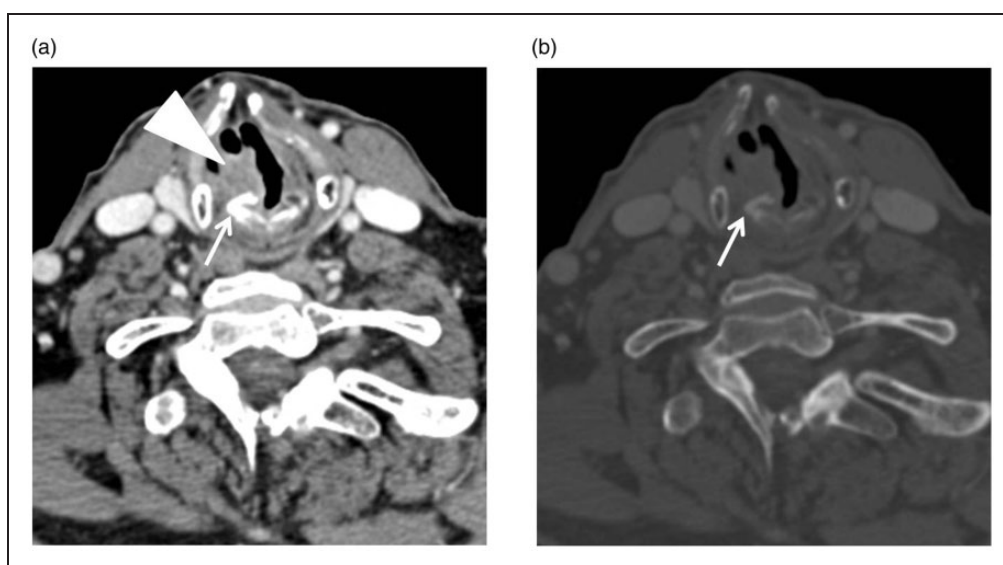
Axial contrast-enhanced computerised tomography (CT) images ((a) soft-tissue window, (b) bone window) obtained in a 76-year-old man with squamous cell carcinoma (SCC) of the right true vocal cord shows asymmetric sclerosis of the vocal process of the arytenoid cartilage (arrow) due to invasion of the tumour (arrowhead).
